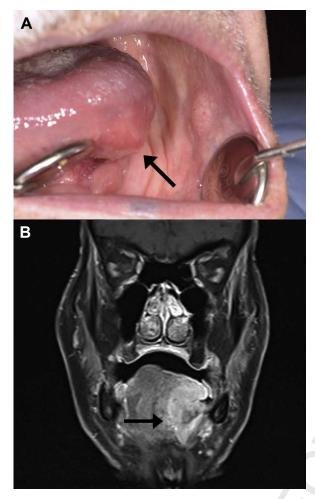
A, Clinical examination showed a nodular, firm, and erythematous swelling involving the left tongue. The smaller nodular lesion seen on the buccal aspect of the edentulous mandibular alveolar ridge was consistent with denture-related fibrous hyperplasia. B, Magnetic resonance imaging (coronal view, T2 weighted) showing a large, ill-defined lesion involving the left tongue and crossing the midline.
